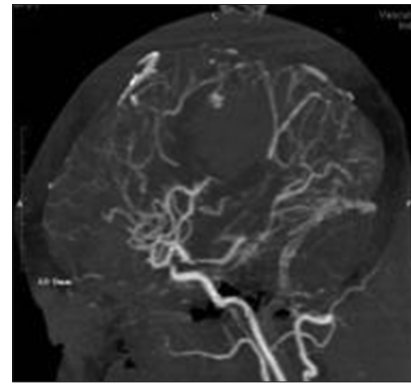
CTA showed small intracranial aneurysm above hematoma
